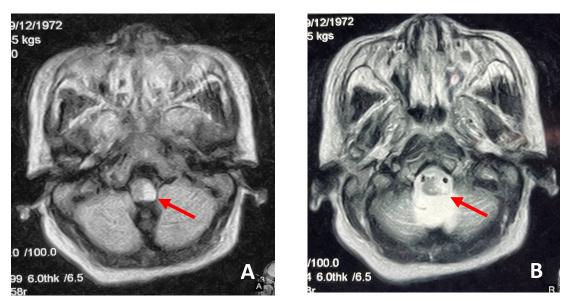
(A) Cranial MRI T1-weighted imaging (T1WI) Axial view at the level of the Medulla revealing a hyperintense lesion involving the left lateral aspect of the medulla oblongata (red arrow); (B) Cranial MRI Fluid-Attenuated Inversion Recovery (FLAIR) Axial view with hyperintense lesion at the left lateral medulla (red arrow).
